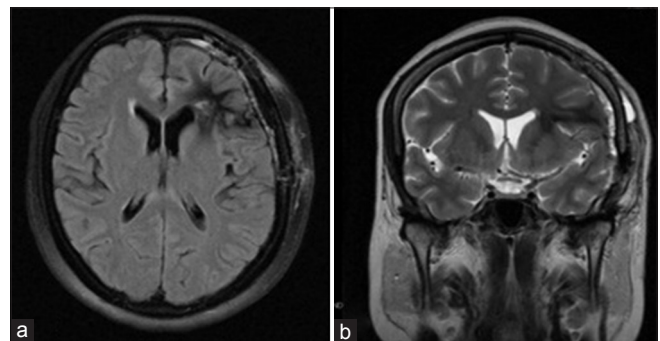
Two months follow-up magnetic resonance imaging. axial Fluid-attenuated inversion recovery sequence (a) and coronal TSE T2 sequence (b) showing the complete excision of the lesion
